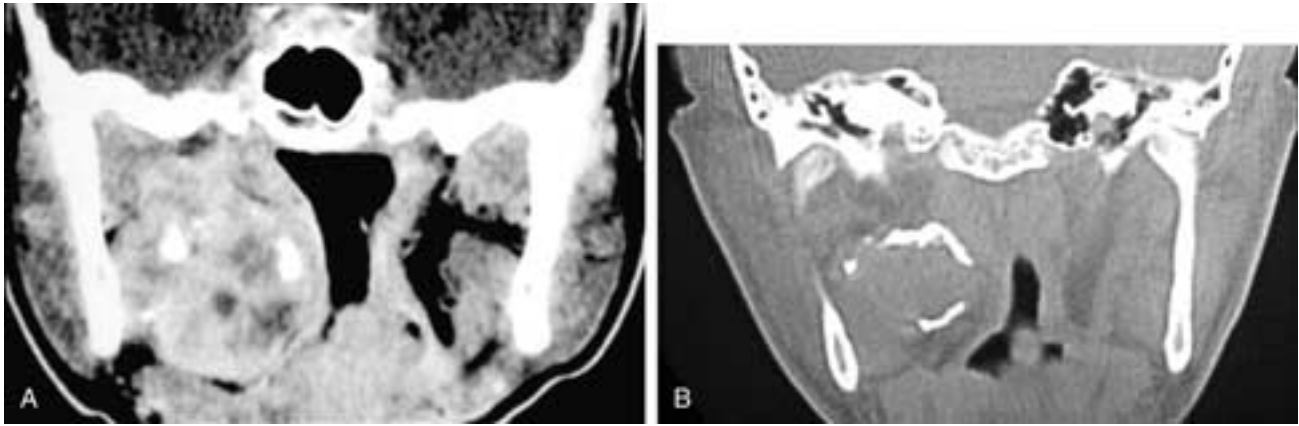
Coronal contrast-enhanced CT scan (A) shows a right pleomorphic adenoma that arose within the deep portion of the parotid gland and extended into the parapharyngeal space. Areas of dystrophic calcification are seen within the tumor matrix, as are areas of cystic degeneration. This appearance is highly suggestive of a pleomorphic adenoma, but occasionally it can be seen in a schwannoma. Coronal CT scan (B) viewed at wide window settings shows a circular area of calcification around the periphery of a right parapharyngeal space mass. Note the difference in the pattern of calcification compared to A. This was an aneurysm of the ICA. Whenever calcifications are seen at the periphery of a mass, an aneurysm must be ruled out by other studies.
